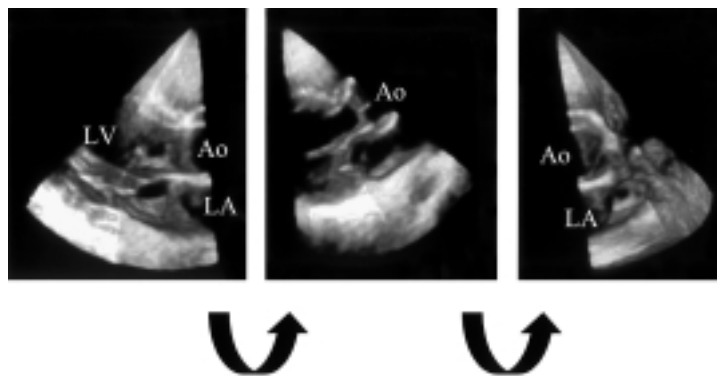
Live three-dimensional pyramidal volume from the parasternal view. Example of three-dimensional images of a normal left ventricle (LV), left atrium (LA) and aortic valve (Ao); volume rendering images are rotated (arrows) instantaneously.
